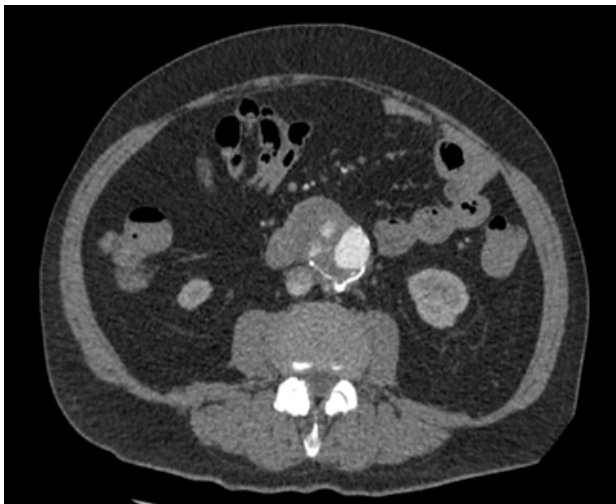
CTA axial view- contrast media extravasation in the duodenum
